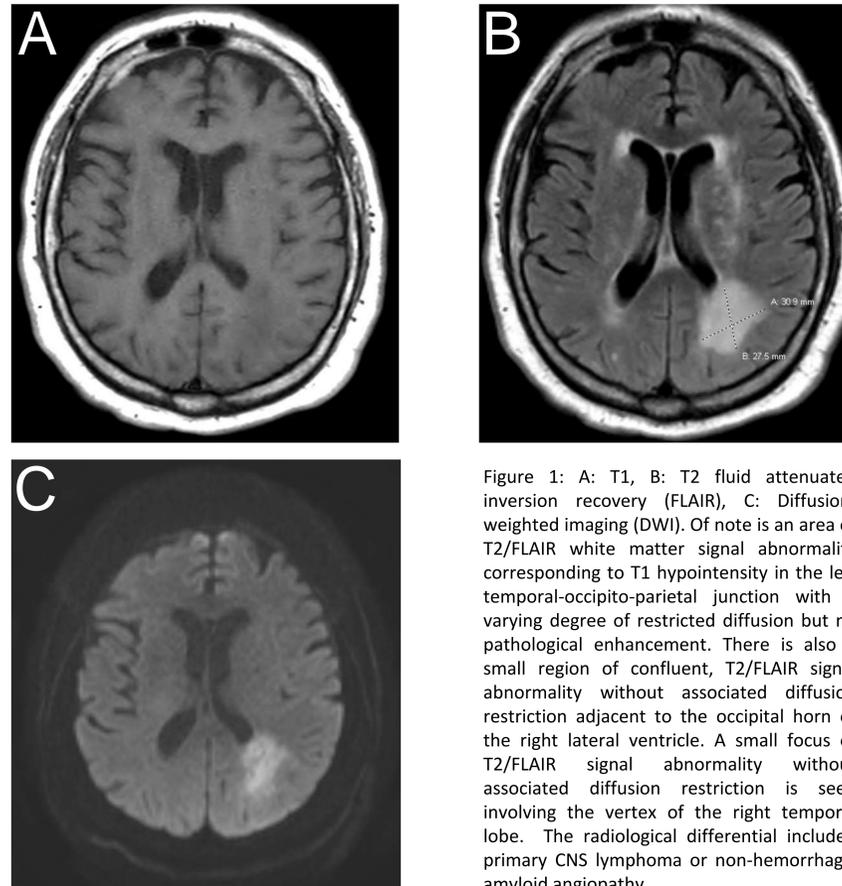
A: T1, B: T2 fluid attenuated inversion recovery (FLAIR), C: Diffusion-weighted imaging (DWI). Of note is an area of T2/FLAIR white matter signal abnormality corresponding to T1 hypointensity in the left temporal-occipito-parietal junction with a varying degree of restricted diffusion but no pathological enhancement. There is also a small region of confluent, T2/FLAIR signal abnormality without associated diffusion restriction adjacent to the occipital horn of the right lateral ventricle. A small focus of T2/FLAIR signal abnormality without associated diffusion restriction is seen involving the vertex of the right temporal lobe. The radiological differential included primary CNS lymphoma or non-hemorrhagic amyloid angiopathy.
